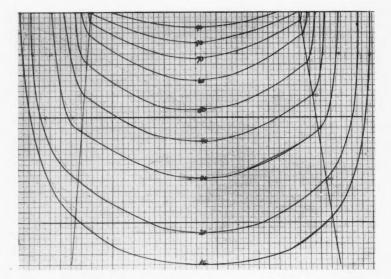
Equal intensity curves measured in water of short wave roentgen rays produced with factors given in text.
